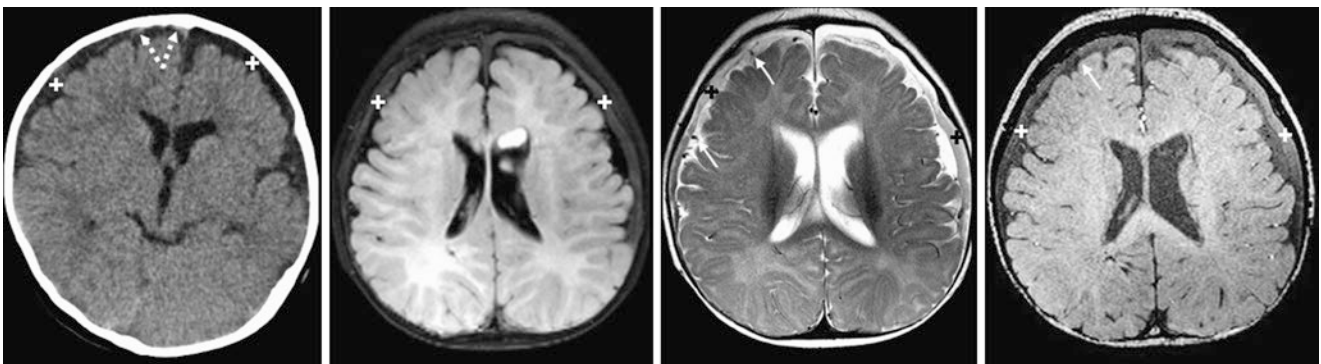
Comparison case of chronic SDHs. In a 5-month-old, NECT (*left*) shows bilateral SDHs (*plus signs*) of the frontal convexities; hypodensity implies that these are chronic. The right SDH has acute hemorrhagic foci (*dotted arrows*). On a 3T MRI, the SDHs did not suppress with CSF on FLAIR (*left middle*). T2WI (*right middle*) and SWI (*right*) show cortical veins displaced inwards (*thin arrows*). A nonaccidental trauma workup was deemed negative
